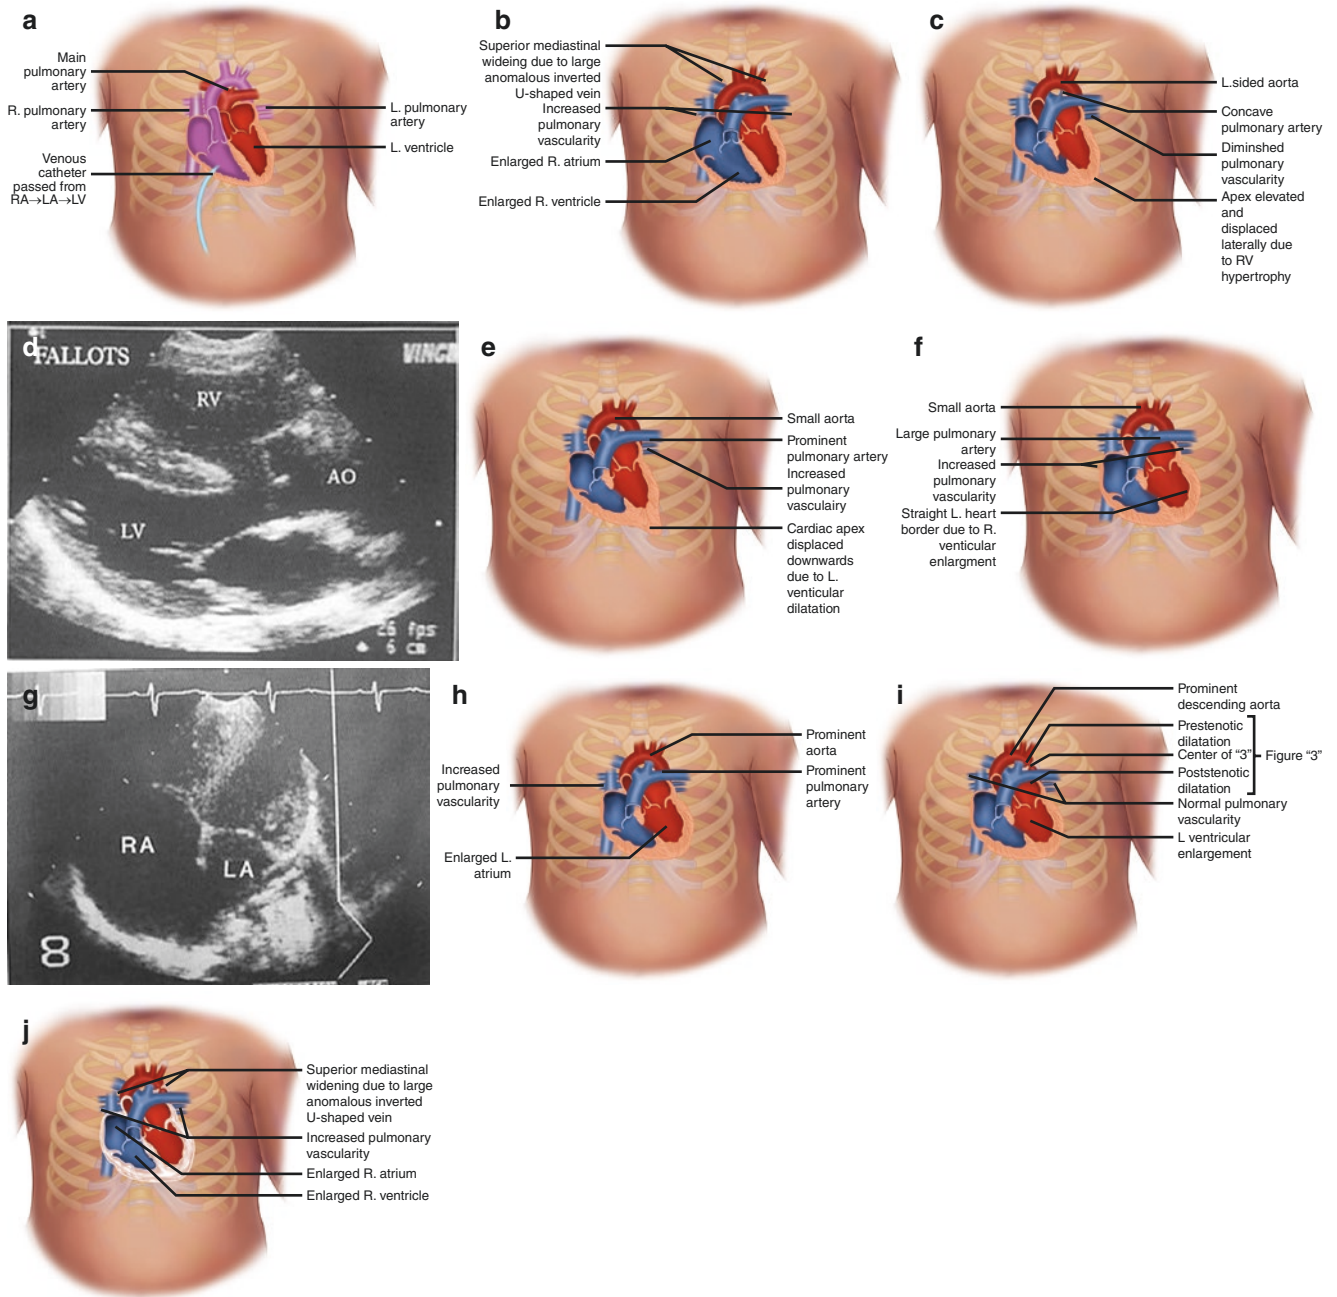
(a) Transposition of the great arteries. (b) TAPVD 1. (c) Tetralogy of Fallot Chest X-ray. Transposition of the great arteries. (d) Two-dimensional echocardiogram of tetralogy of Fallot. The right and left ventricle are separated. (e) Chest X ray of ventricular septal defect. (f) ASD. (g) Two-dimensional echocardiogram of ASD. (h) Patent ductus arteriosus scan. (i) Coarctation of the aorta “Figure 3 sign”. (j) Pericardial effusion
